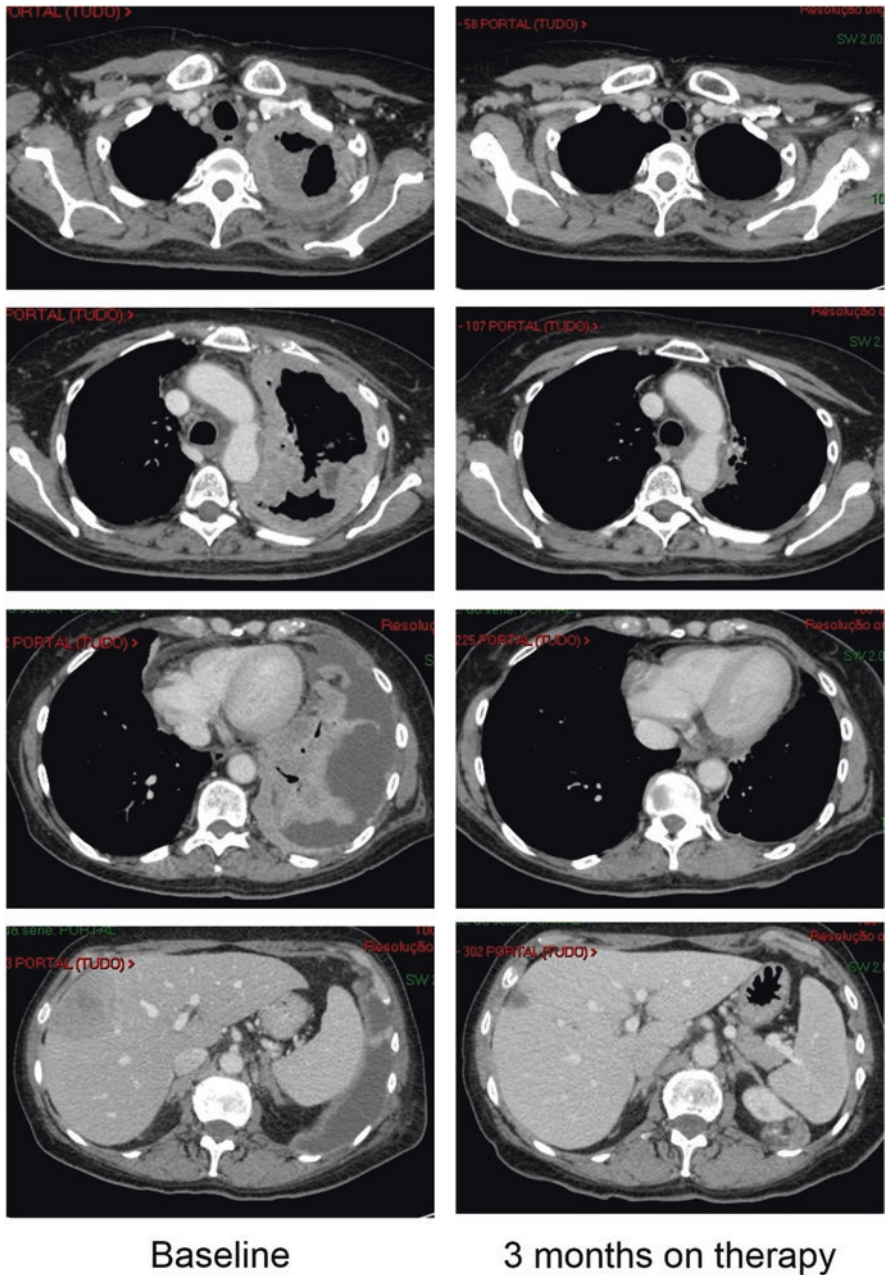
Computed tomography (CT) of the chest and abdomen with mediastinal window. Left side: significant irregular pleural thickening with intense, neoplastic enhancement, associated with a moderate pleural effusion on the same side, leading to parenchymal atelectasis in the left lower lobe. Below a large liver metastasis shown as subcapsular mass in the right lobe of the liver. Right side: complete regression of neoplastic pleural thickening and pleural effusion and significant volume reduction of the liver metastatic mass after osimertinib (bottom image)
